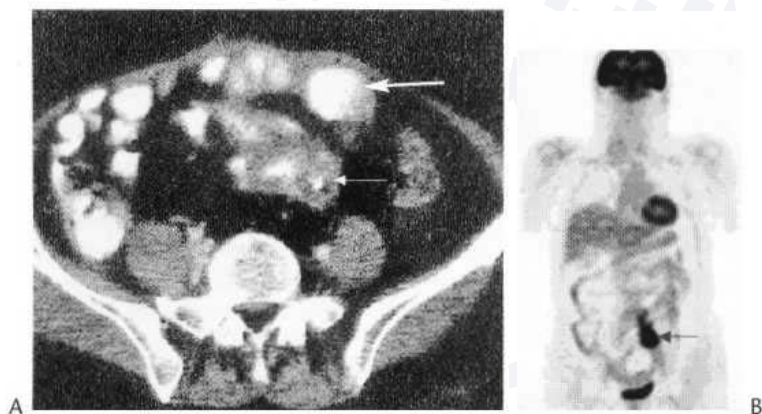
Following surgery for colorectal cancer CT (A) shows indeterminate soft-tissue thickening (arrow), FDG-PET image (B) shows an intensely active focus at the site of recurrent tumour (arrow). (Courtesy of Professor P. J. Ell, Institute of Nuclear Medicine, Middlesex Hospital, London.)
